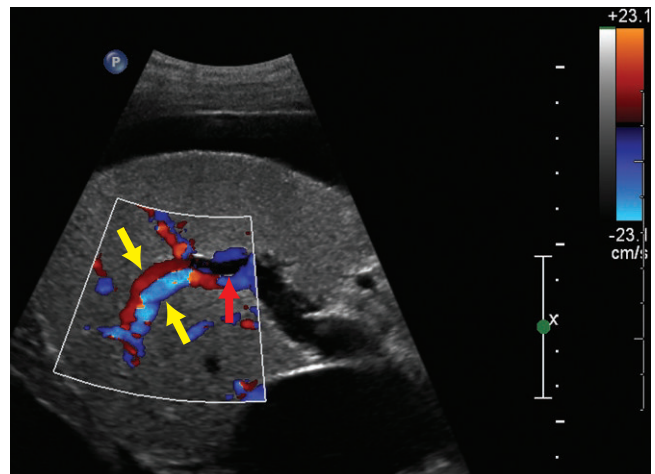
Color Doppler of the right lobe shows the adjacent portal vein and hepatic artery (between yellow arrows). The hepatic artery always flows into the liver and it is blue. The portal vein should also be flowing into the liver but it is red indicating hepatofugal flow. Near 90° (red arrow), the color is undetectable due to the poor Doppler angle.
